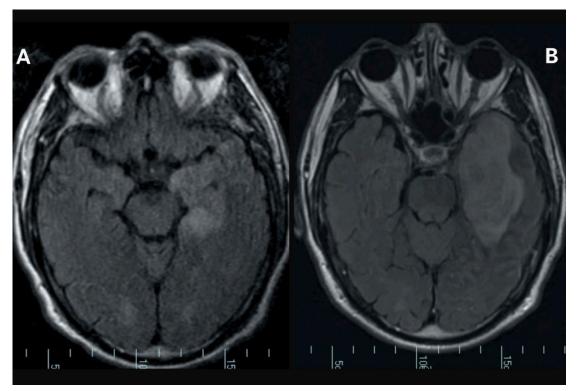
(A) Cerebral MRI of a 72-year-old man, performed first-day post- thrombolysis.
